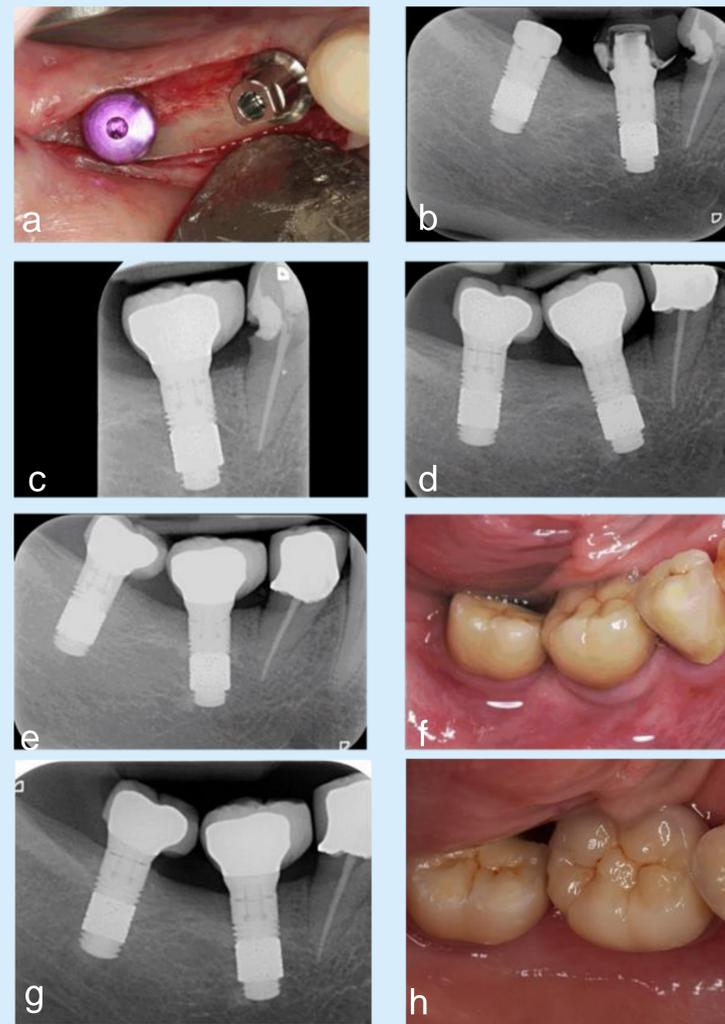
Radiographs and clinical views of a female patient in the IL study presented with a healed edentulous space in the mandibular right first molar area for placement (a) and sufficient stabilization (b) of a TM dental implant (4.7mmD x 10mmL). After 2 weeks a final restoration (c) was delivered. The implant maintained soft tissue levels and exhibited no complications at the 1- (d), 2- (e, f) and 3- (g, h) year follow-up visits. At the 3-year visit, the implant was stable and fully functional with minimal crestal bone loss (0.12 mm). The TM implant in the mandibular right second molar area was a non-study implant followed conventional loading. Case contributed by Dr Markus Schlee.
